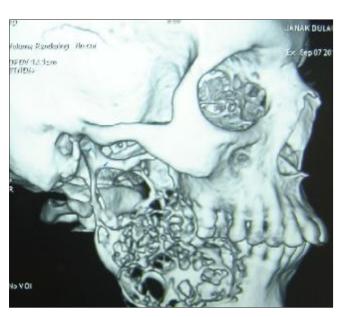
(d): CT scan (3D reconstruction view) showing almost complete involvement of left mandible with multiple areas of perforation.
